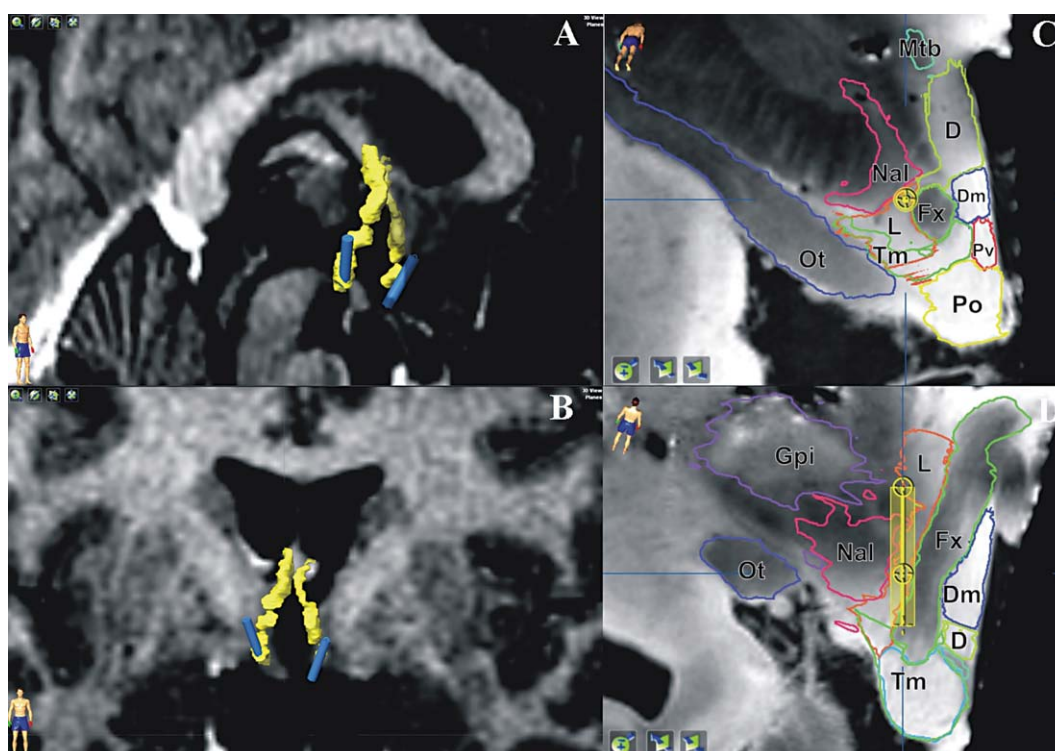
Location of the electrodes within the hypothalamus. A, B) Antero-lateral (A) and frontal (B) 3D views showing the location of the four-contact electrodes (blue cylinders) close to the fornices (yellow; manual segmentation); sagittal (A) and coronal (B) MRI slices going through the hypothalamus are displayed. C, D) Co-registration of the right electrode (according to stereotactic coordinates relative to the midpoint along the commissural plane) with the stereotactic 3D 4.7-T MRI atlas; perpendicular (C) and parallel (D) reconstructed slices along the electrode axis are displayed. All the contacts were located near the fornix within the hypothalamus [41]: fornix (Fx); mamillary body within the tuberomammillary nucleus (Tm); mamillo-thalamic bundle (Mtb); optic tract (Ot); globus pallidum internus (Gpi); nucleus of the ansa lenticularis (Nal); lateral (L), dorsal (D), dorso-medial (Dm), paraventricular (Pv) and pre-optic (Po) hypothalamic nuclei.
